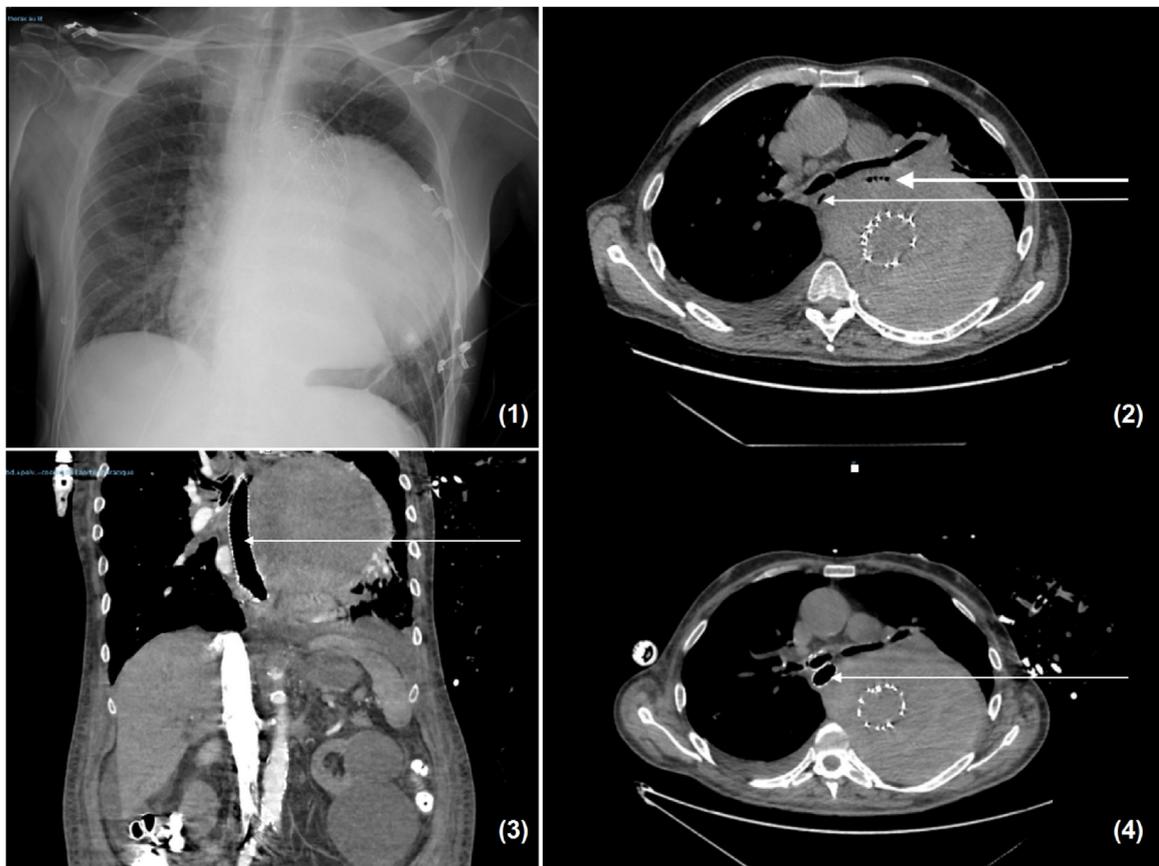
Aneurysm on several images: (1) Chest X-ray showing the 16 cm diameter aneurysm, treated by endovascular repair. Chest CT scan without contrast showing oesophageal compression (thin arrow) and air in the aneurysm sac (large arrow) signing posterior mediastinitis, before (2) and after (3;4) endoscopic treatment.
